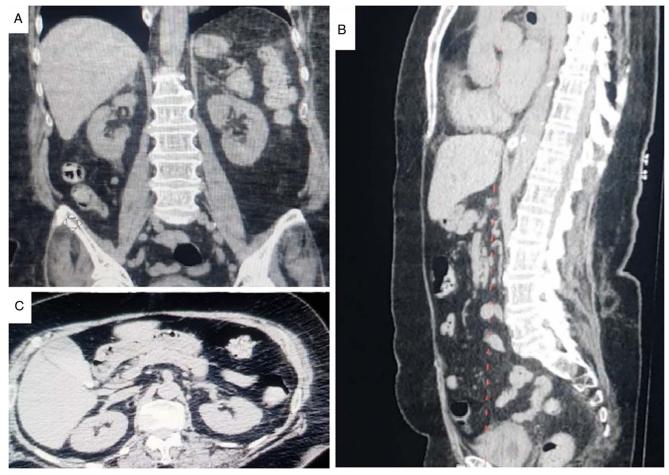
A nonenhanced CT scan of the abdomen, A. coronal view, B. sagittal view, C. axial view, all A, B, and C show no pathology.
